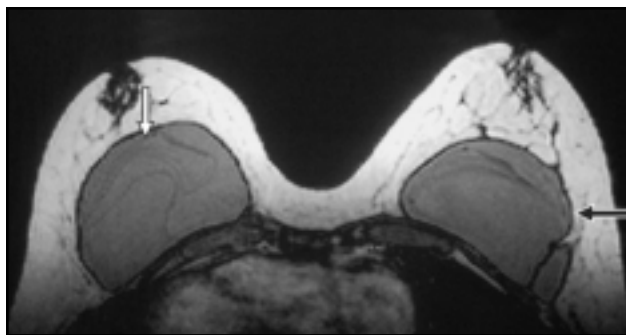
T1-weighted axial MR image showing capsule herniation of the silicone implant (black arrow) and the linguine sign of intracapsular rupture (white arrow).
